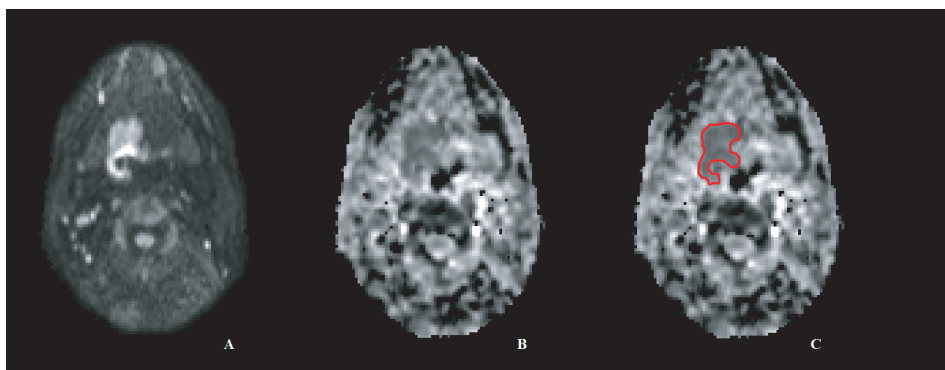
Images of a patient with a T4aN2c oropharyngeal carcinoma. DW-MRI acquired in 2011. A: DW-MRI b800 s/mm² image, B: corresponding ADC map, C: corresponding ADC map with the contour used to determine the median ADC value of the tumor.
